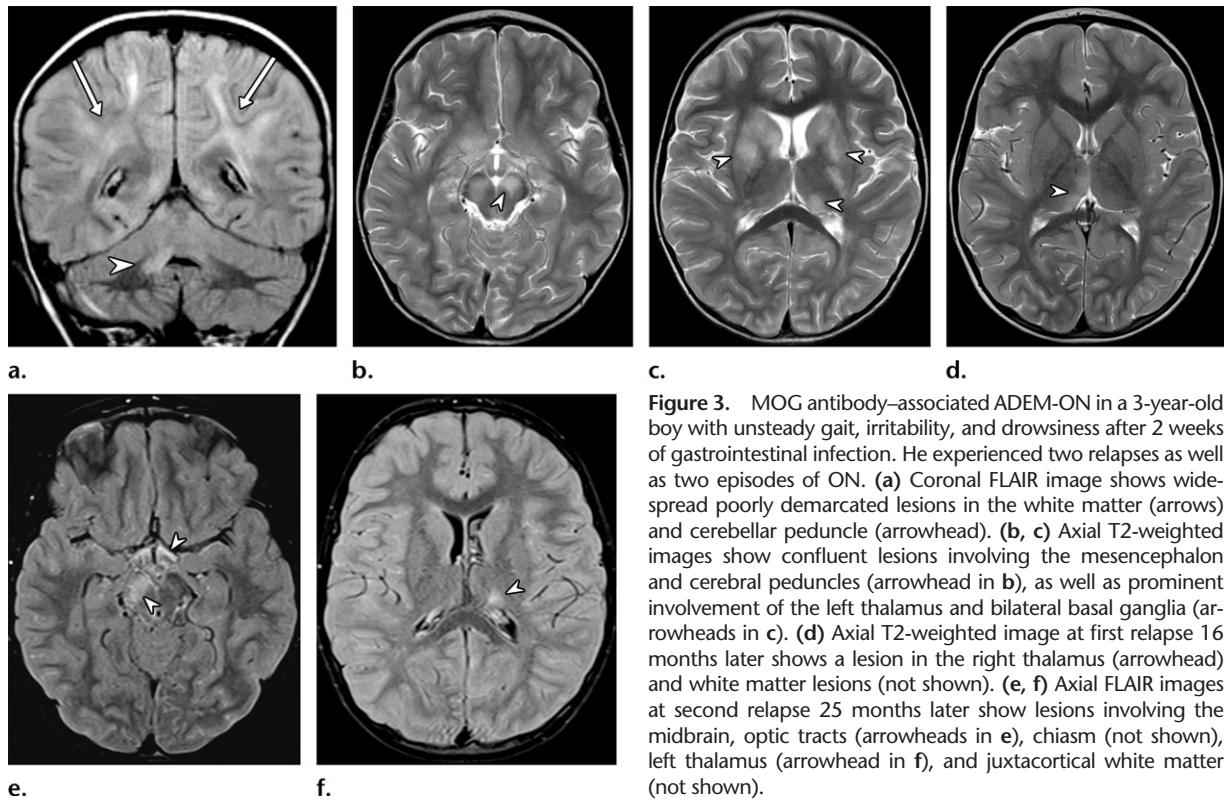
MOG antibody–associated ADEM-ON in a 3-year-old boy with unsteady gait, irritability, and drowsiness after 2 weeks of gastrointestinal infection. He experienced two relapses as well as two episodes of ON. (a) Coronal FLAIR image shows widespread poorly demarcated lesions in the white matter (arrows) and cerebellar peduncle (arrowhead). (b, c) Axial T2-weighted images show confluent lesions involving the mesencephalon and cerebral peduncles (arrowhead in b), as well as prominent involvement of the left thalamus and bilateral basal ganglia (arrowheads in c). (d) Axial T2-weighted image at first relapse 16 months later shows a lesion in the right thalamus (arrowhead) and white matter lesions (not shown). (e, f) Axial FLAIR images at second relapse 25 months later show lesions involving the midbrain, optic tracts (arrowheads in e), chiasm (not shown), left thalamus (arrowhead in f), and juxtacortical white matter (not shown).
